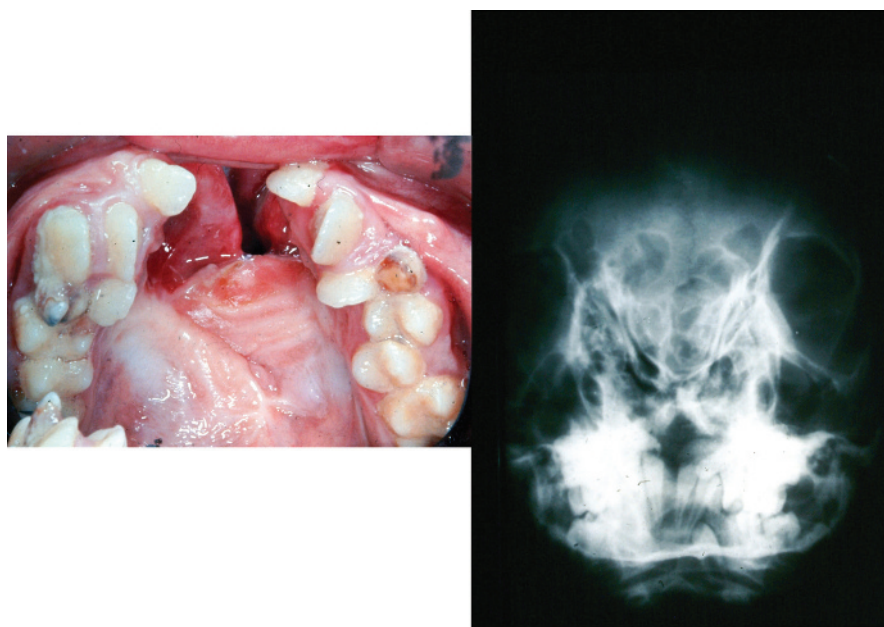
Patients maxilla with two premaxillae plus skull semi-axial radiograph.
